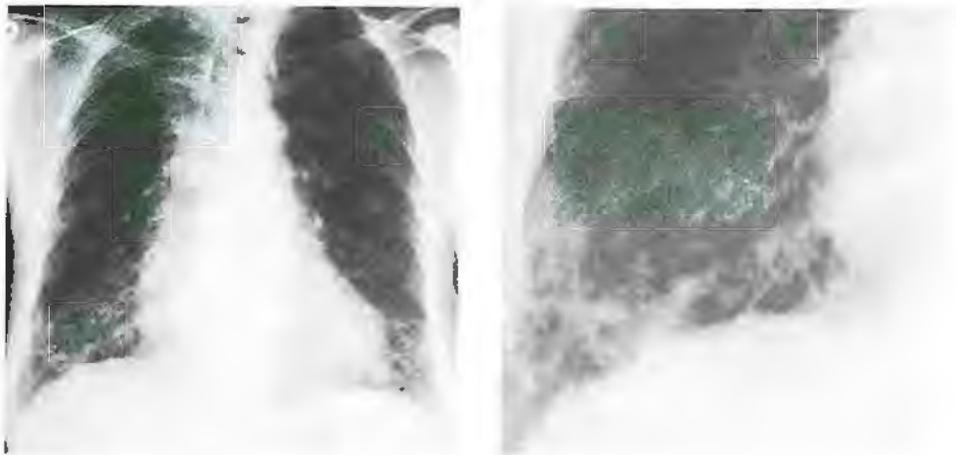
A chest radiograph of asbestosis with a close-up view of the right lower lung.
